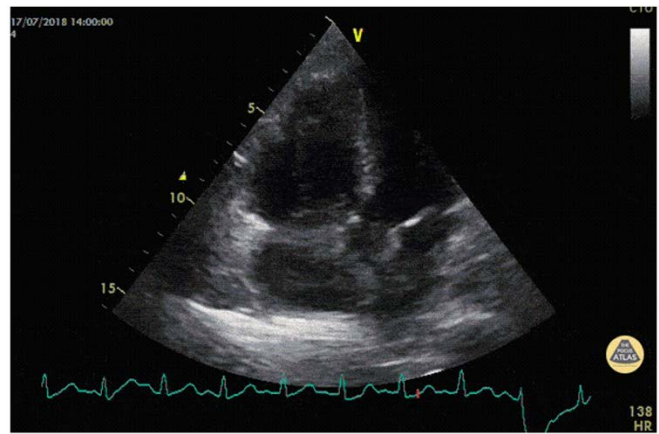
Transthoracic Echocardiography (POCUS) Apical 4 chamber view. Dilated RV with interventricular septum flattening and McConnell's Sign demonstrated by RV wall hypokinesia with preserved apical contractility.⁵
